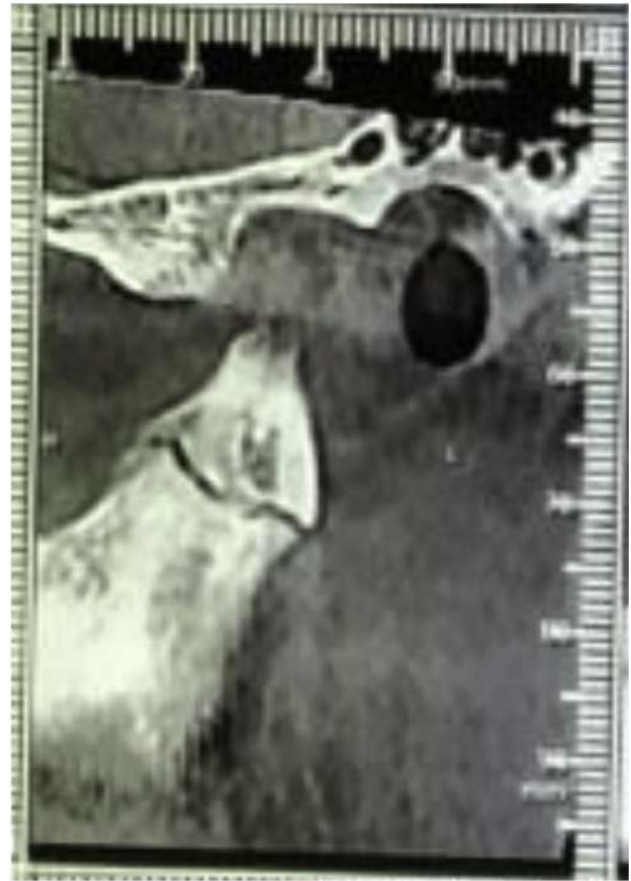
Radiographic image showing post traumatic degenerative changes in the left temporomandibular joint.
